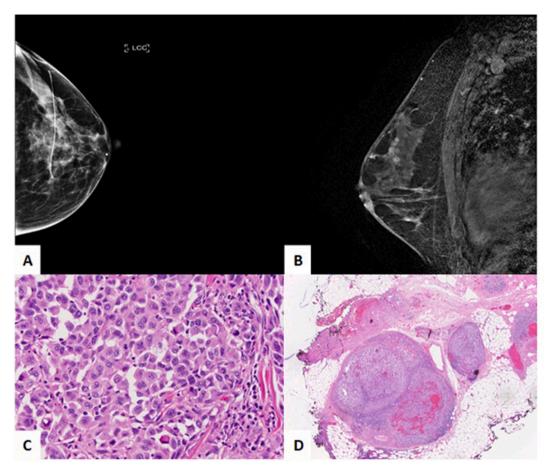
(Case 3): A. Diagnostic mammogram demonstrating a $1 \times 0.4 \times 1$ cm retro-areolar superficial nonvascular complex nodule at 6 o'clock with adjacent duct ectasia. B. Diagnostic MRI shows metastatic nodules at 12 o'clock extending into the central breast. C. High power view of the melanoma in the breast. The cells are epithelioid/plasmacytoid with abundant eosinophilic cytoplasm and irregular nuclei, high N:C ratio and mitotic figures. (400x). D. Several lymph nodes with melanoma metastases, demonstrate a clear capsule and a rim of lymphocytes. Normal breast parenchyma can be seen in the upper right corner. (40x).
